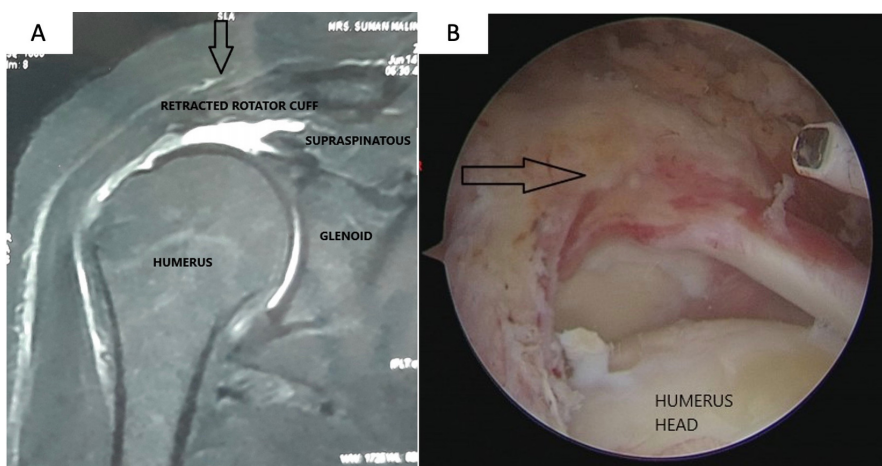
Pre-operative retracted cuff. A: Coronal MRI cuts showing the retracted cuff. B: Arthroscopic images showing retracted cuff (Arrow)
